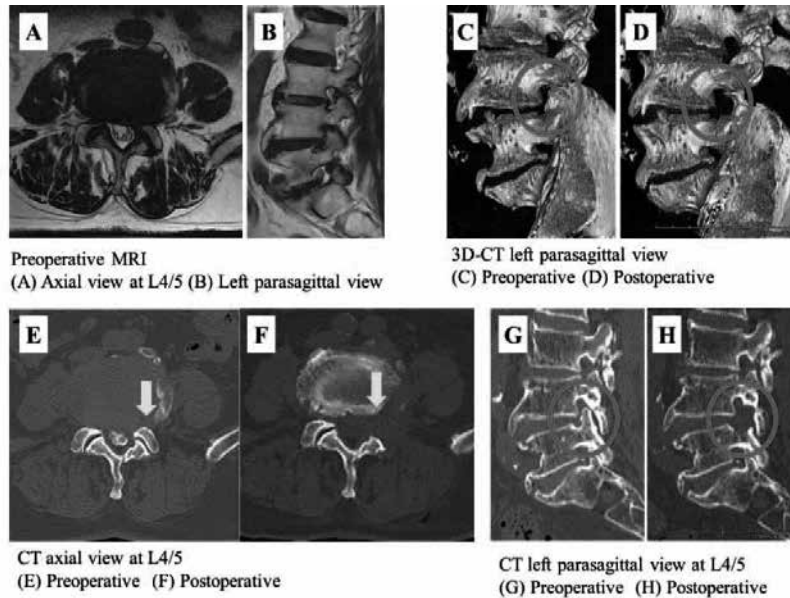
Case 2. (A) Preoperative axial MRI scan shows a herniated nucleus pulposus at L4/5. (B) Preoperative sagittal MRI scan shows foraminal stenosis on the left side at L4/5. (E, F) Axial CT scan at L4/5 confirms complete resection of the superior articular process (arrow) and enlargement of the lateral recess after surgery. (C, G) Preoperative 3D (C) and sagittal (G) CT scans show left-sided bony foraminal stenosis at L4/5. (D, H) Postoperative 3D (D) and sagittal (H) CT scans confirm total resection of the superior articular process and partial resection of the L5 pedicle (circle), resulting in enlargement of the L4/5 foramen after surgery. 3D, 3-dimensional; MRI, magnetic resonance imaging; CT, computed tomography
